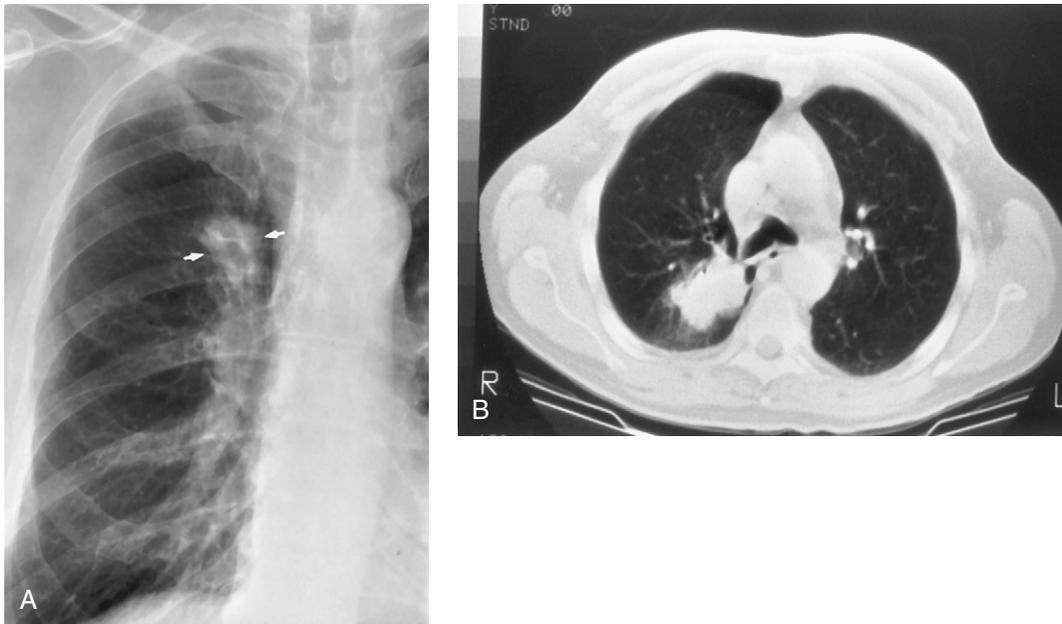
Lung mass in blastomycosis. (A) PA chest radiograph of an asymptomatic 62-year-old man demonstrates an irregularly margined mass (arrows) above the hilum in the right upper lobe. (B) Chest CT image (lung window) reveals a lobulated opacity adjacent to the right main bronchus. Lobectomy with nodal dissection demonstrated granulomatous pneumonitis and lymphadenitis secondary to blastomycosis.
